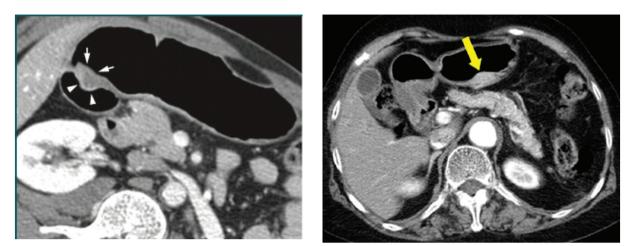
(Left) Ectopic pancreas at gastric antrum. CECT shows an ill-defined flat-ovoid 1.4-cm endoluminal submucosal mass (arrows) in the anterior wall of the gastric prepyloric antrum. The lesion shows heterogeneous enhancement and low attenuation. Note the prominent enhancement and mild thickening of the overlying mucosal layer (arrowheads). [Kim J., Ectopic Pancreas: CT Findings with Emphasis on Differentiation from Small Gastrointestinal Stromal Tumor and Leiomyoma.] (Right) Heterotopic pancreas in stomach. CT image shows an enhancing mass (arrow) in gastric antrum. The mass reveals ill-defined border and endophytic growth. [Kim S., Various congenital abnormalities and anatomic variants of the pancreas: A pictorial review]
